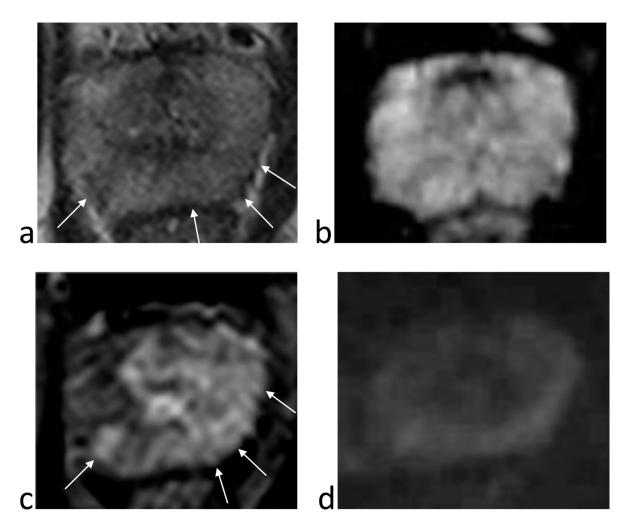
Axial images from an indetermnate MRI (scoring 3/5) with no tumour found at biopsy. The T2 image (a) shows diffuse, but slightly heterogenous, moderate reduction in signal in the peripheral zone on each side (arrows). The contrast-enhanced image (b) shows moderate enhancement in a similar distribution (arrows). No significantly restricted diffusion is seen on the ADC map (c) and long b diffusion image (d).
